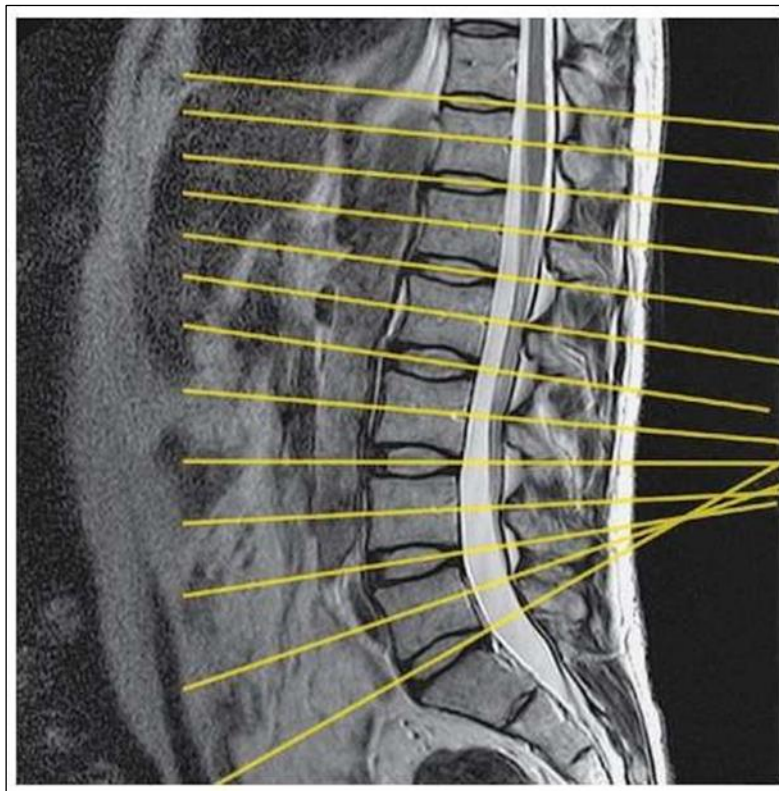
Sagittal FSE T2-weighted image of the lumbar spine showing axial/oblique slice prescription for arachnoiditis. (Westbrook, 2014)
